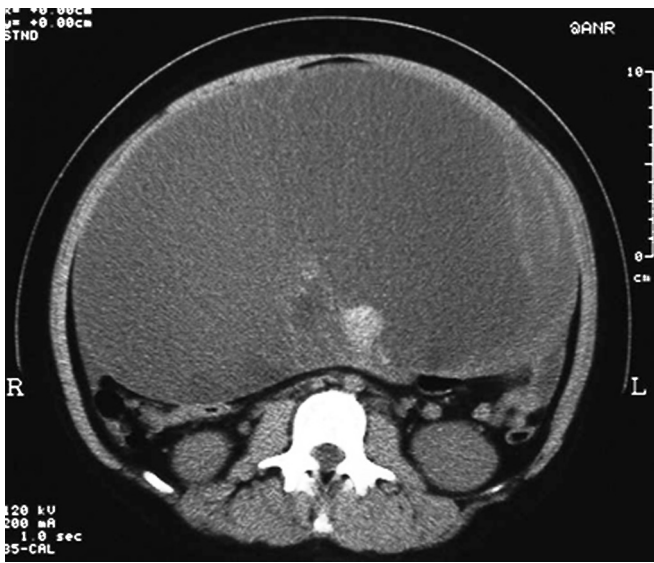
Computed tomography (CT) scans confirmed the presence of a very large solid cystic mass in the lower abdomen.
